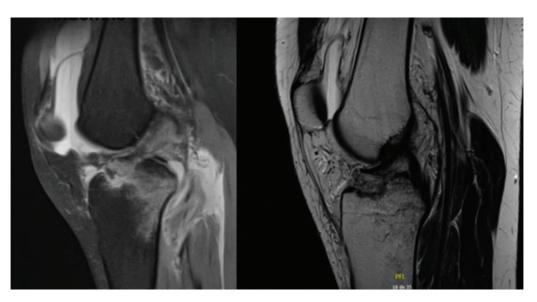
Sagittal MRI projections of PD TSE FS and TSE T2 sequences showing avulsion of the tibial spines with interposition of the anterior horn of the medial meniscus. Grade 3 of the Green and Tuca classification.
